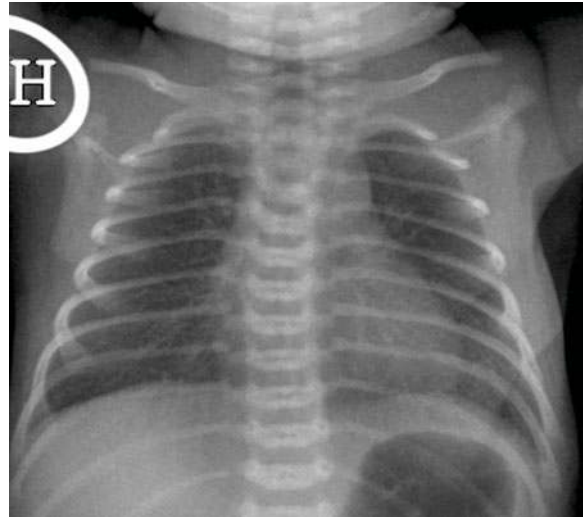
A 1-day-old girl. Correct chest radiograph. The clavicles and ribs are symmetrical, and the diaphragm is at the level of the ninth posterior costae. Gastric air is seen in normal position
